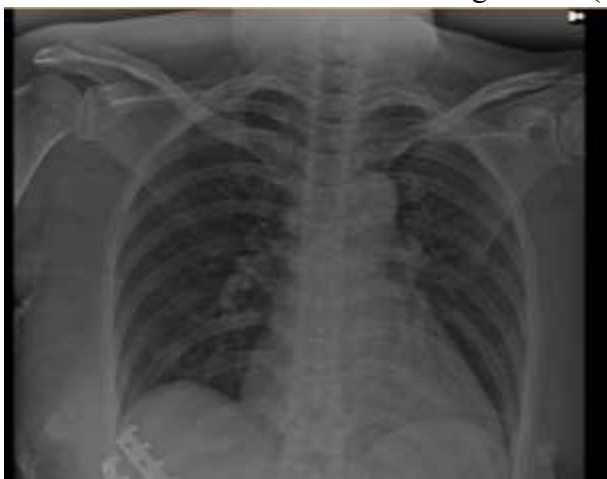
Postoperative chest X-ray confirming appropriate SHAPP plate placement and rib alignment
